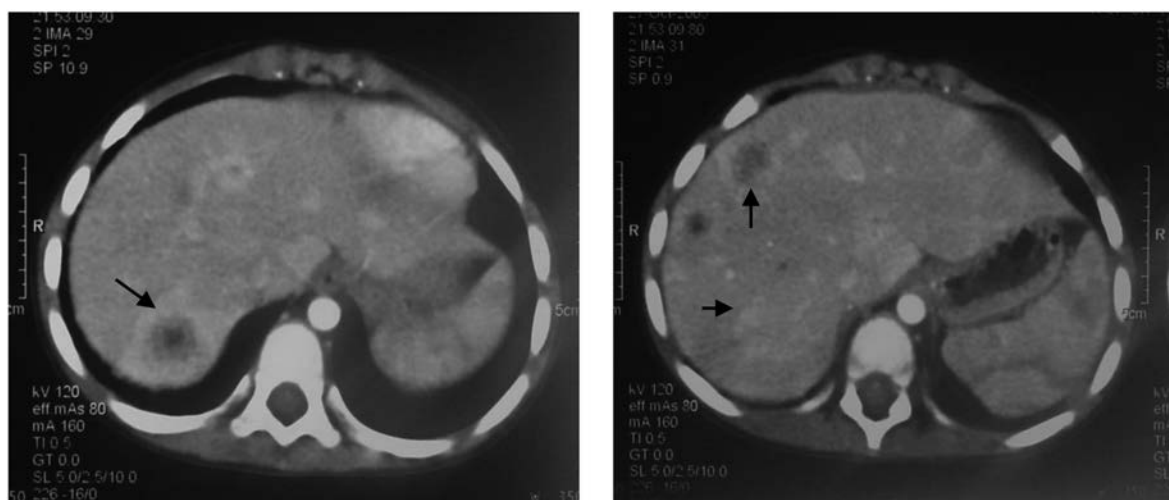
MRI of the abdomen with hypoechoic, necrotic nodules in the liver.
